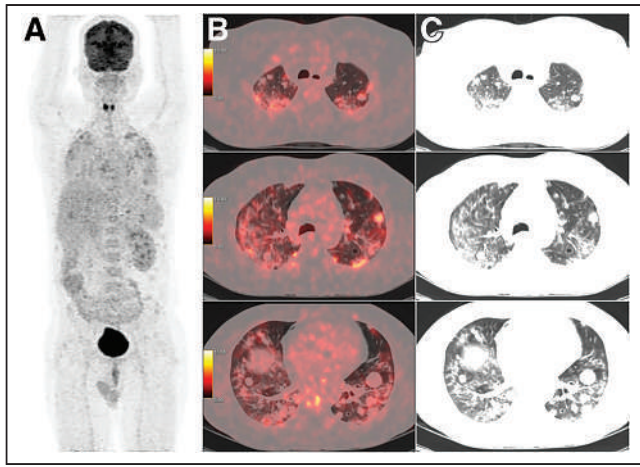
¹⁸F-FDG PET/CT whole-body maximum-intensity-projection image (A), axial PET/CT images (B), and corresponding CT images (C) showing ¹⁸F-FDG-avid diffuse ground-glass opacities/patchy consolidatory changes bilaterally in lung fields from apex to base, obscuring details of metastatic lesions (SUV_{max} of hottest nodule, 7.8; SUV_{max} of ground-glass opacities, 7.3).
